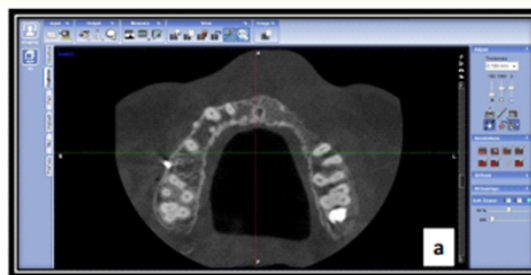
Figure a: The axial images were scrolled to detect the radiographic apex (Axial view)
